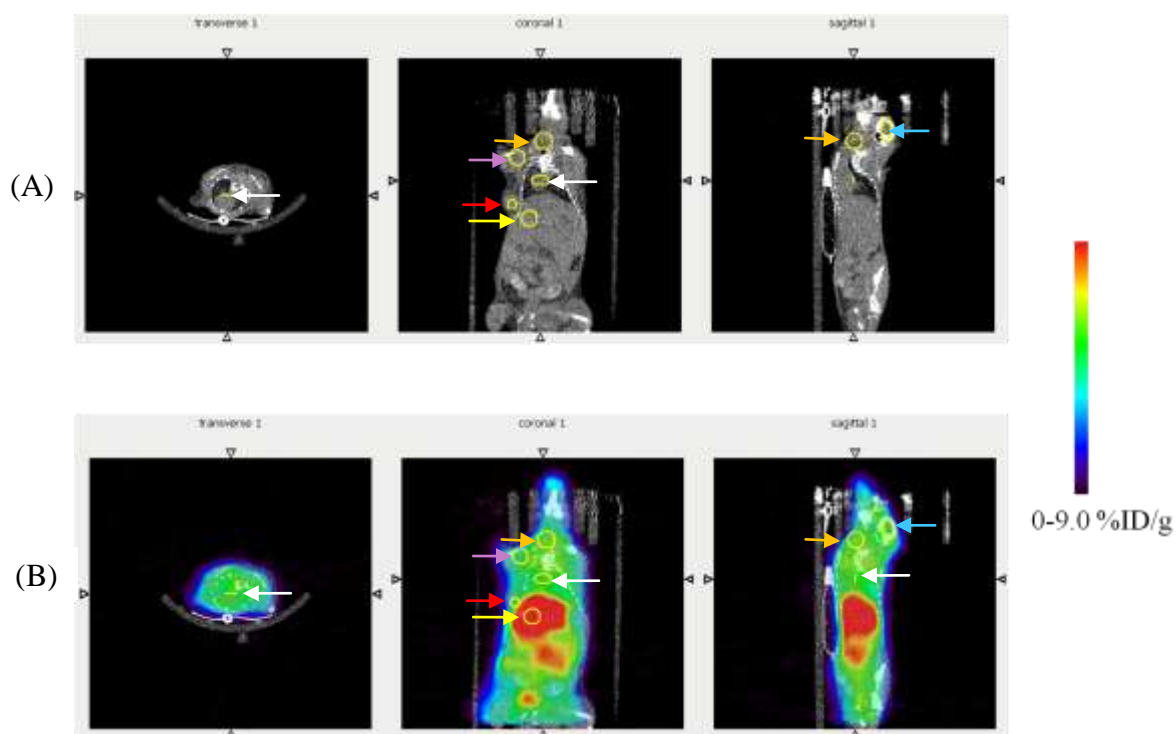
Dynamic PET image 65-66 minute pi. ROIs for tumour (coronal view; red arrow), liver (coronal view; yellow arrow), throat (coronal and sagittal view; orange arrow), front leg muscle (coronal view; purple arrow) and heart (transverse, coronal and sagittal view, white arrow). (A) CT, (B) PET/CT image. PET colour indicating 0 - 9.0% ID/g
